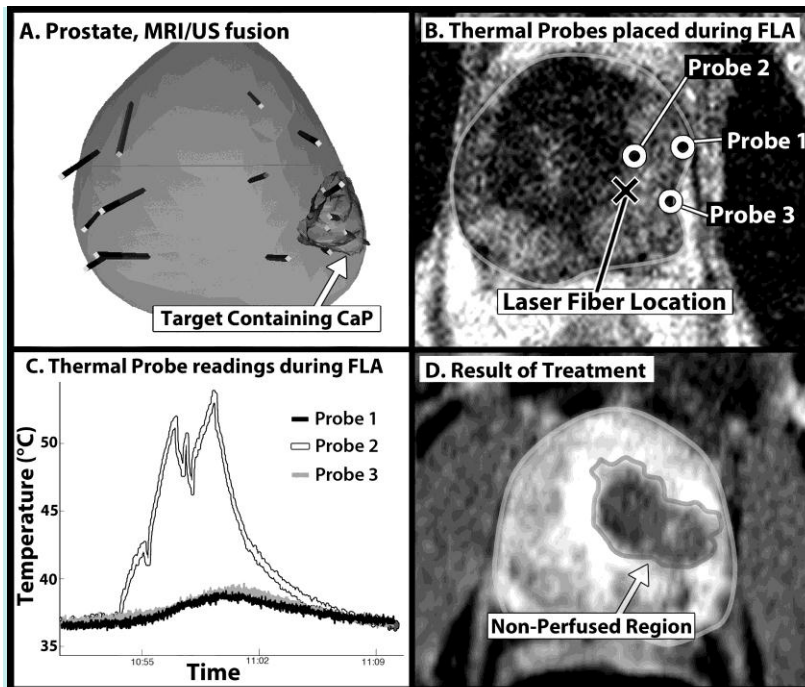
Example of 59 yr-old man with (A) biopsy-confirmed GS7 CaP within the MRI target. (B) During FLA, MRI-independent thermal probes record real-time temperatures in prostate. (C) Temperature near laser (probe 2) rises to 55 C, but probes away from laser show little change. (D) Post-treatment MRI shows non-perfused area (5 'burns' used) and thermal effect confined within the prostate.
